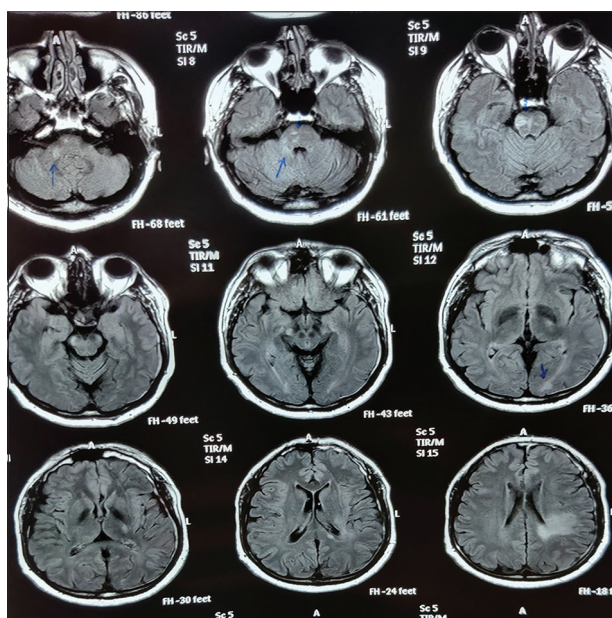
Post recovery FLAIR axial images show moderate resolution of lesion in left parietal, left occipital white matter, pons and brachium pontis
